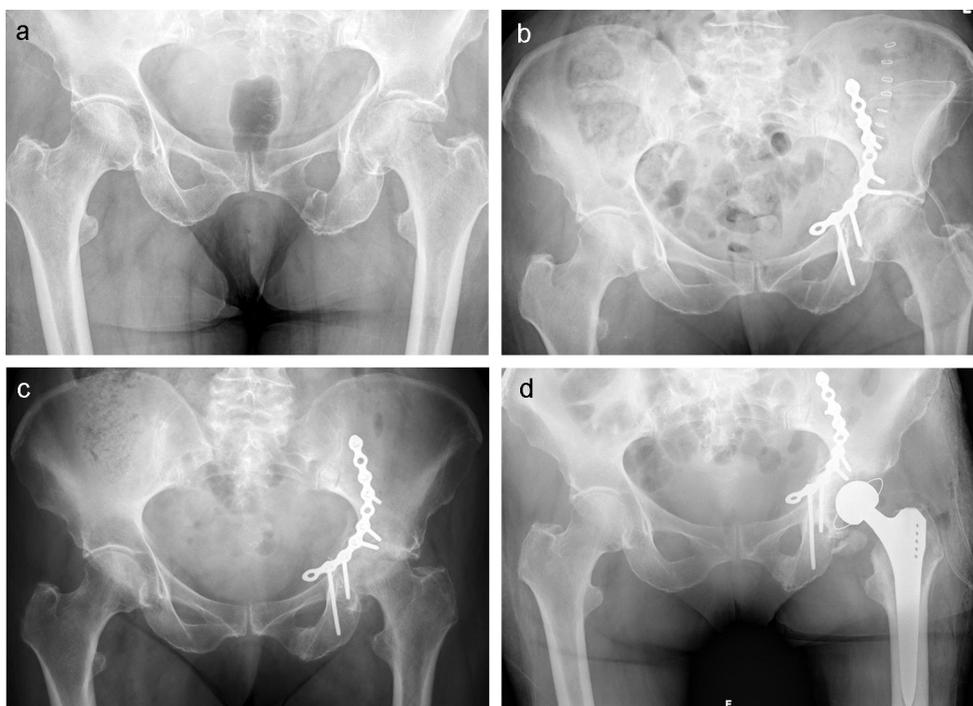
(a) Anteroposterior radiograph of a 78-year-old patient who sustained an acetabular fracture of the anterior column with posterior hemitransverse, medial displacement of the quadrilateral plate, central displacement of the femoral head, impaction of the acetabular dome (“gull” sign) and of the femoral head due to low-energy fall. The pre-operative image is shown. (b) Anteroposterior radiograph presenting the postoperative image with anatomic fracture reduction with desimpaction of the osteochondral acetabular dome fragment using the femoral head as a template, filling of the defect with synthetic bone and definitive fracture fixation. (c) Anteroposterior radiograph 4 months after surgery. An acetabular dome fragment and an impaction fracture of the femoral head might have resulted in severe posttraumatic osteoarthritis with poor radiographic grading according to the Matta criteria at the early follow-up. (d) Anteroposterior radiograph 4 months after surgery. Due to severe posttraumatic osteoarthritis revision surgery was necessary with conversion to a total hip replacement at this time point.
